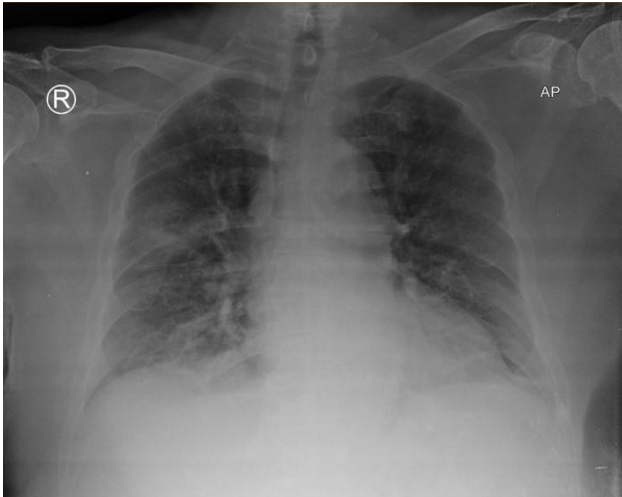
Chest X-Ray Followed up on clinic, one week after discharged
